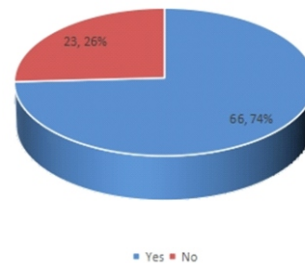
Radiologist verification of ultrasound report findings done by non-radiologists (n = 89)
